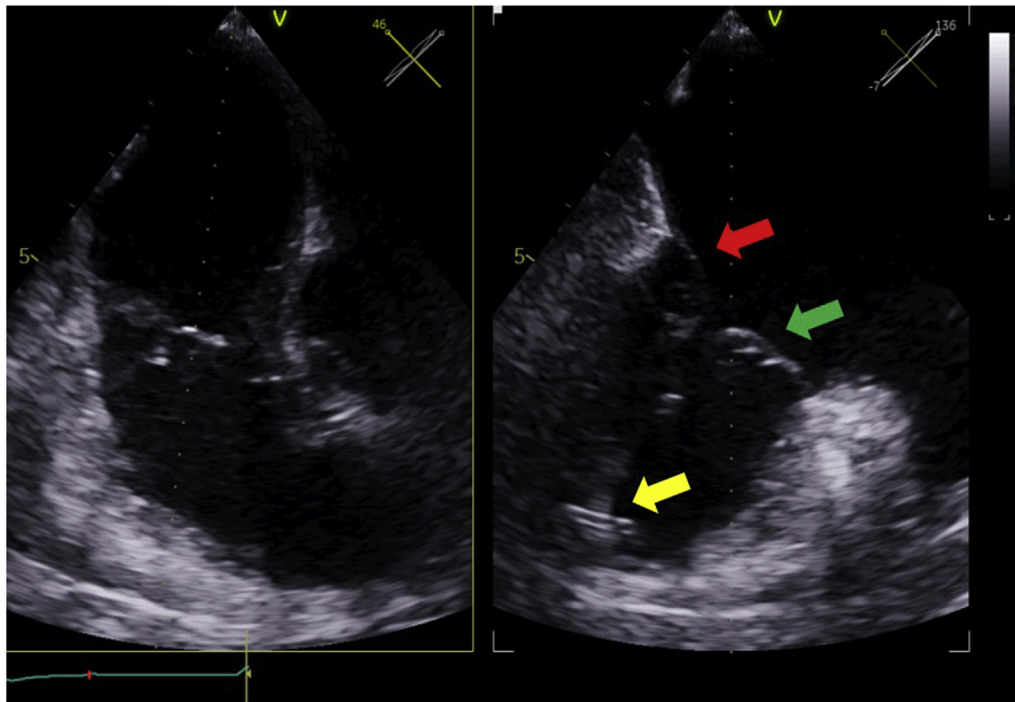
Transesophageal echocardiogram with biplane imaging across the TV (RV inflow-outflow view at 45°) from a deep esophageal view showing the LP in the RV apex (yellow arrow). The LP is shown to be interacting with the subvalvular apparatus, with consequent papillary muscle and chordae tendinae restriction; leaflet tethering of the septal leaflet is shown by the red arrow, and leaflet tethering of the anterior leaflet is shown by the green arrow.
